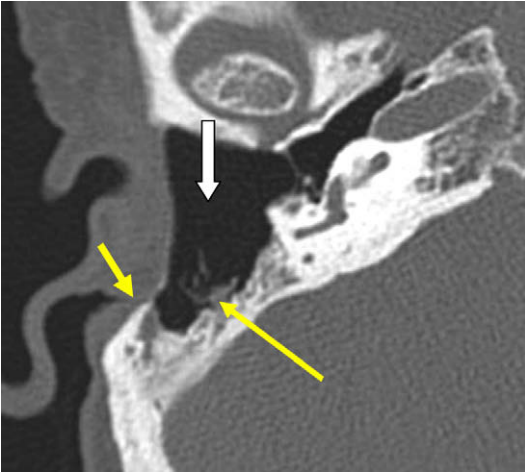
Axial CT after open tympanomastoidectomy. Note absence of the posterior canal wall (*white arrow*). Debris or residual inflammatory disease is commonly seen within residual air cells or adjacent to irregular bony margins with “overhanging” edges (*yellow arrows*). Note that the remainder of the mastoid is well aerated and free of disease.
